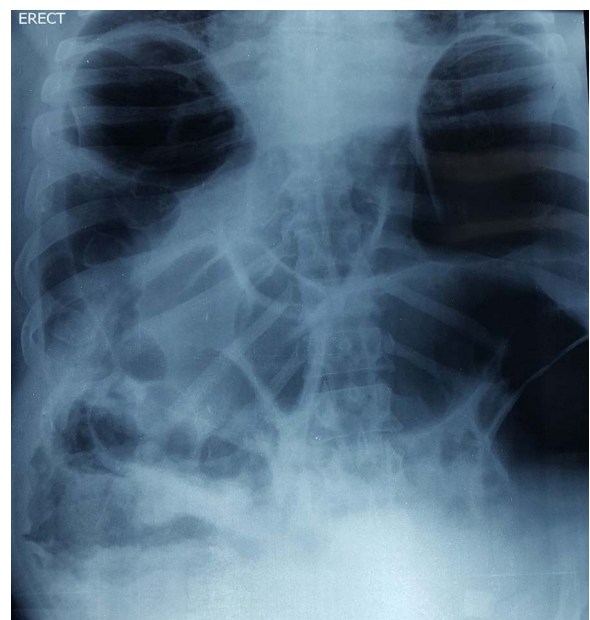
Abdominal X-rays demonstrating dilated loops of large bowel.
